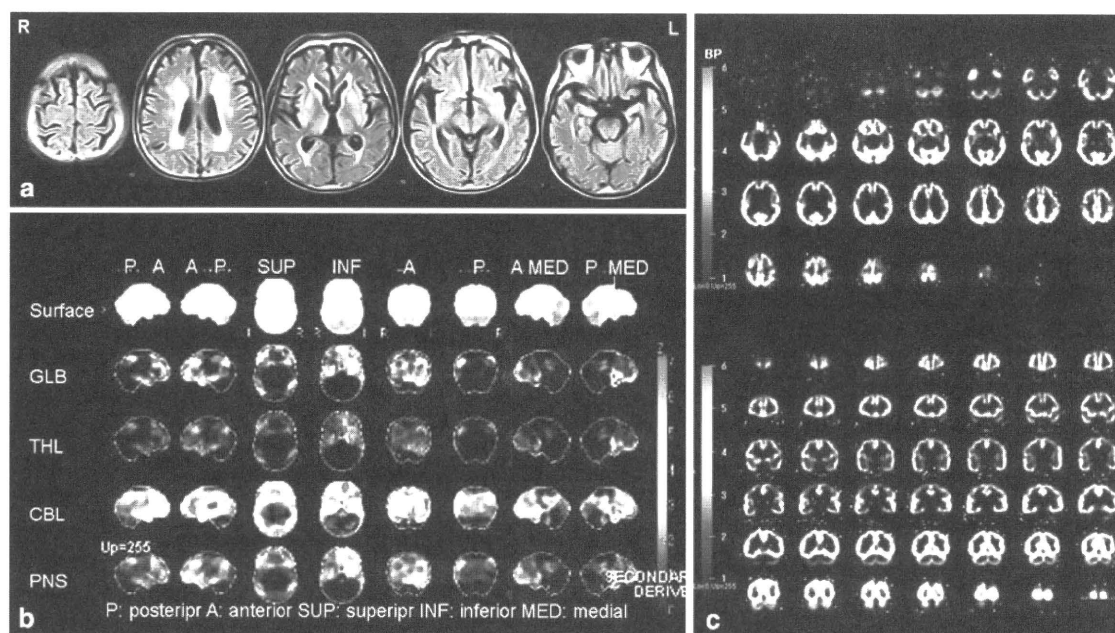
Neuroimaging. a Magnetic resonance imaging of the patient using the fluid-attenuated inversion recovery method showed marked cortical atrophy accompanied with multiple ischemic lesions in the bilateral corona radiate, medial temporal lobe and brainstem. b ^{123}I IMP SPECT, three-dimensional stereotaxic surface projection images. GLB (the second row) shows Z score images normalized by
